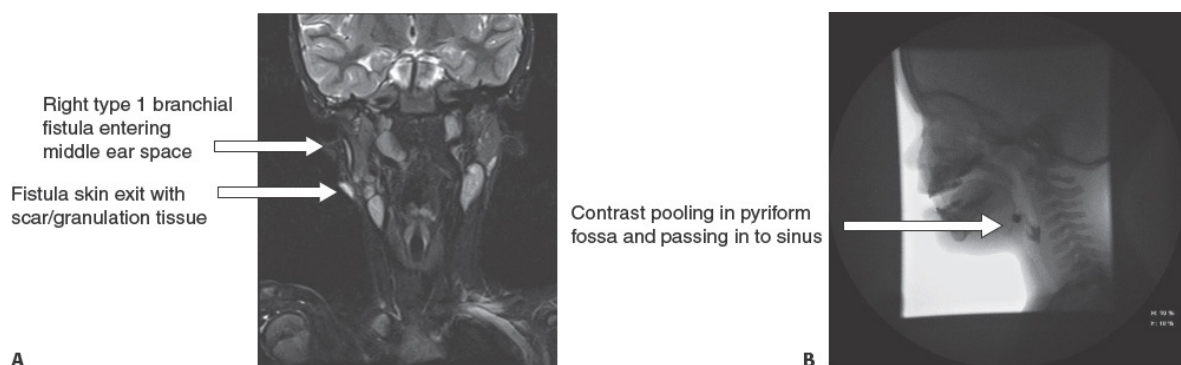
• A. MRI of type 1 branchial fistula. B. Sinogram of type 3 branchial sinus.
